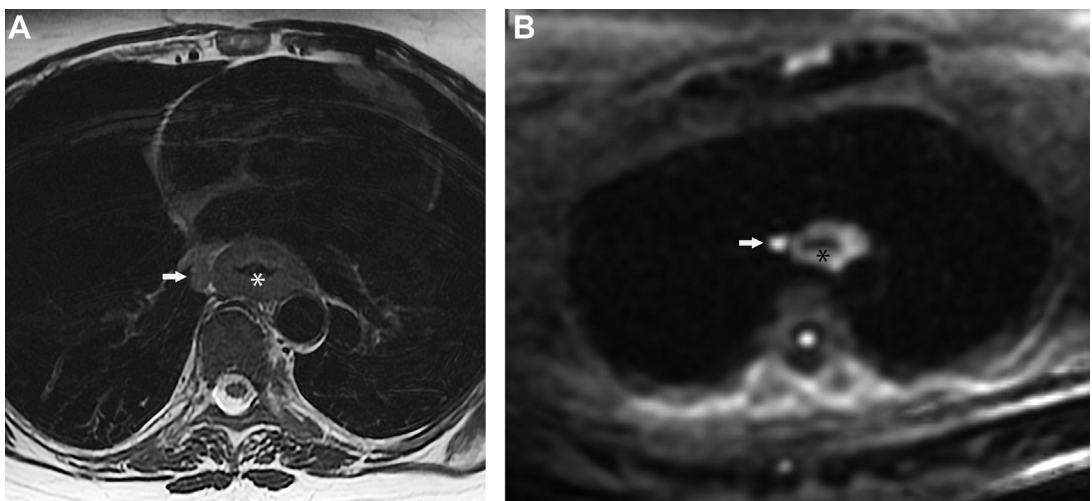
(A) Axial T2-weighted MR image shows diffuse thickening of the distal esophagus consistent with a primary malignancy (asterisk). There is an adjacent enlarged lymph node (arrow) suspicious for lymph node metastasis. (B) Axial DWI at the same level shows high signal intensity within the esophageal wall (asterisk) and an adjacent lymph node (arrow), consistent with malignancy.
